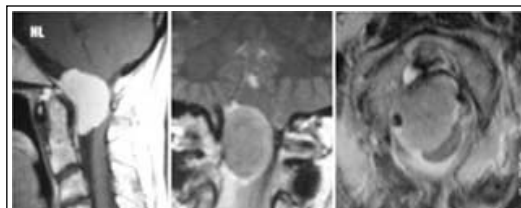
MRI T1. Foramen magnum meningioma (Anterior lateral localization).
